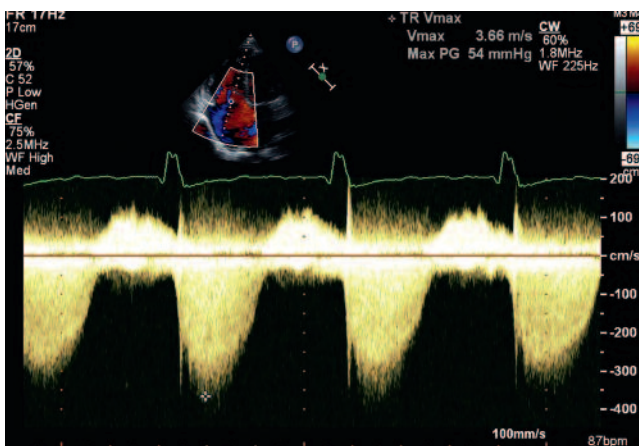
Resting right ventricle: right atrium pressure gradient of 54 mmHg on continuous wave Doppler.
